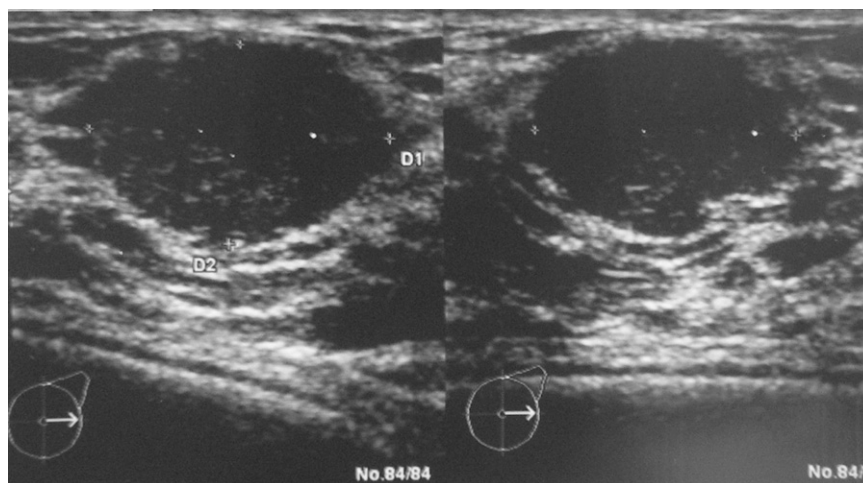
Sonography of a fibroadenoma in a transsexual woman.
